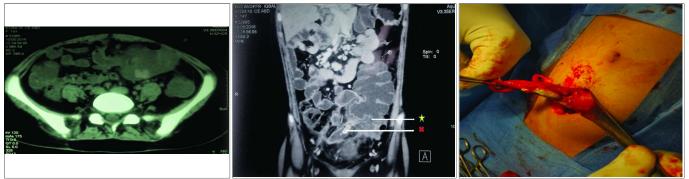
CT scan image of the patient showing left-sided caecum and appendix.
